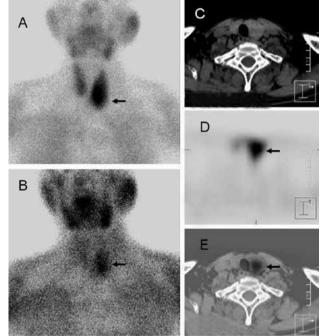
Dual-phase ^{99m}Tc-sestamibi parathyroid scintigraphy and SPECT/CT scans of the patient. (A) Early imaging of dual-phase ^{99m}Tc-sestamibi parathyroid scintigraphy. Thyroid gland was developed clearly, and high radiotracer uptake was revealed at the lower pole of the left thyroid lobe. (B) Delayed imaging of dual-phase ^{99m}Tc-sestamibi parathyroid scintigraphy. The radioactivity was decreased in the thyroid gland, and high radiotracer uptake was still revealed at the lower pole of the left thyroid lobe. (C, D, E) Hybrid SPECT/CT scans. High radiotracer uptake posterior to the left thyroid lobe coincided with a mass in parathyroid gland through CT scan. Hybrid SPECT/CT scans suggested a left parathyroid adenoma.
